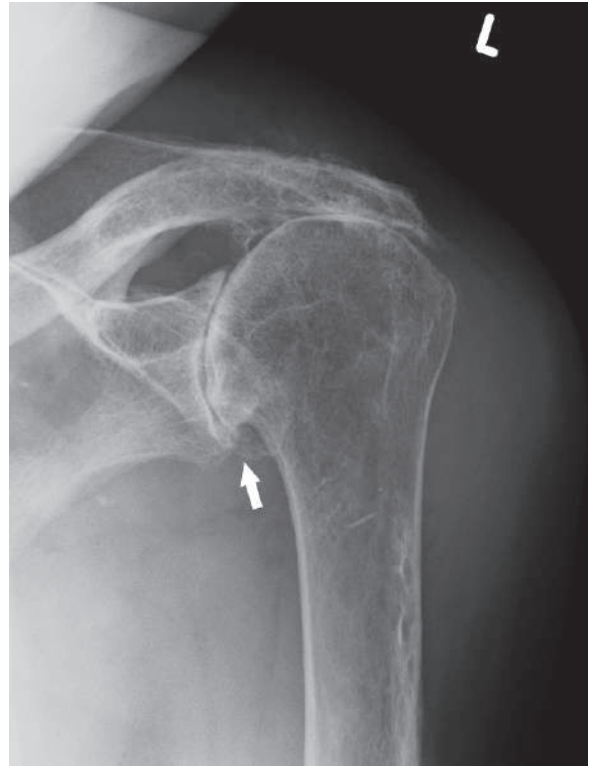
Plain shoulder radiograph shows the classical signs of OA: narrowing of the joint space, sclerosis of the humeral head and the glenoid fossa, and osteophyte formation at the base of the humeral head (arrow)
